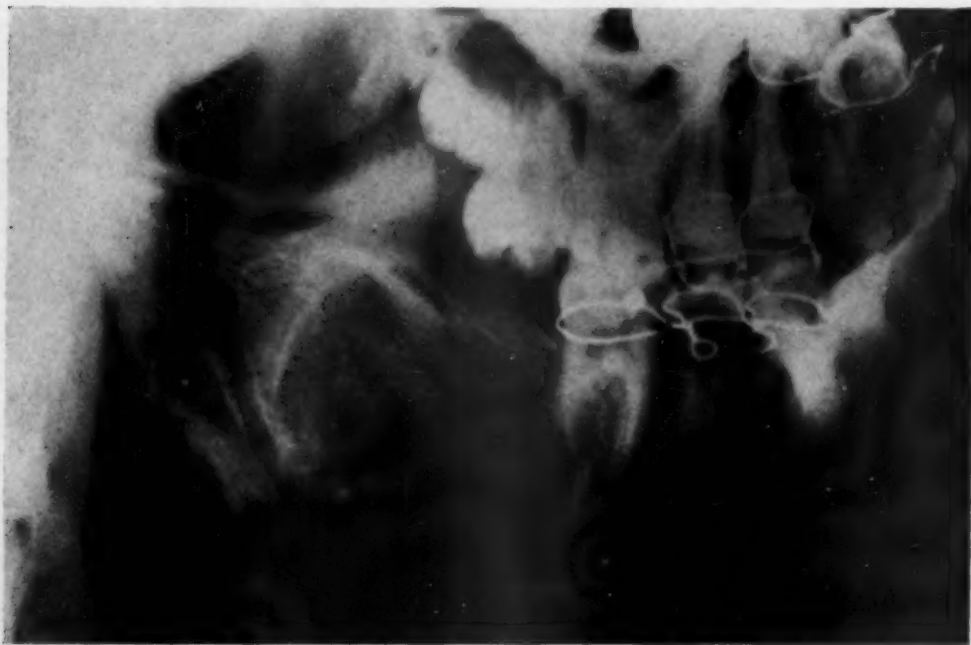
Postoperative roentgenogram of left mandible one week after removal of tumor mass and tooth. The teeth had been wired before operation and rubber bands were worn for five weeks beginning the day after operation. (Pl. 8313.)
